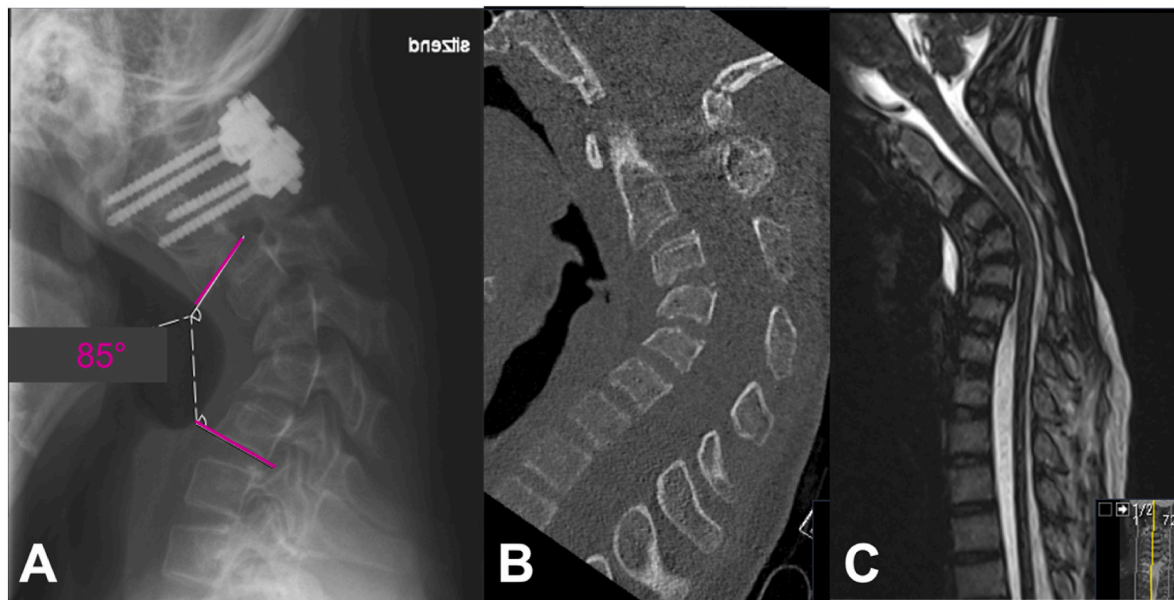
A Lateral plain sitting radiograph of the cervical spine with a C2-C7 Cobb angle of 85° B sagittal CT view C sagittal T2-weighted MRI view (all imaging after 8 weeks of halo fixation).
